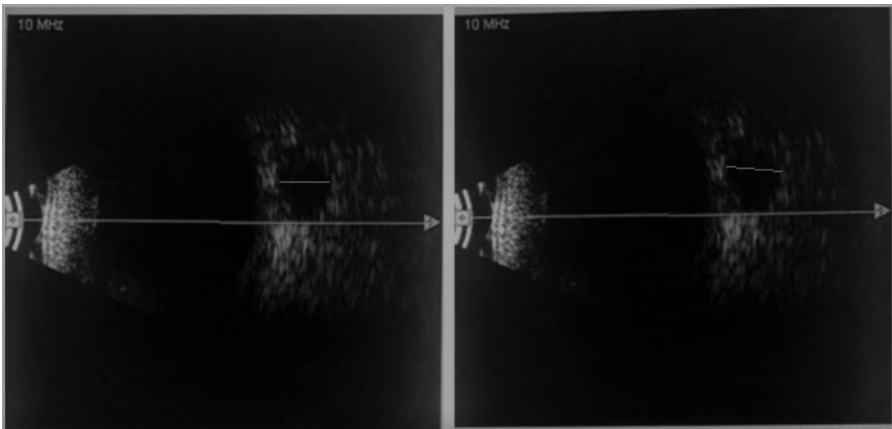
B-scan ultrasound cross-section of retrobulbar optic nerve showing optic nerve sheath diameter at presentation (5.2 mm in the right eye and 5.1 mm in the left eye).
